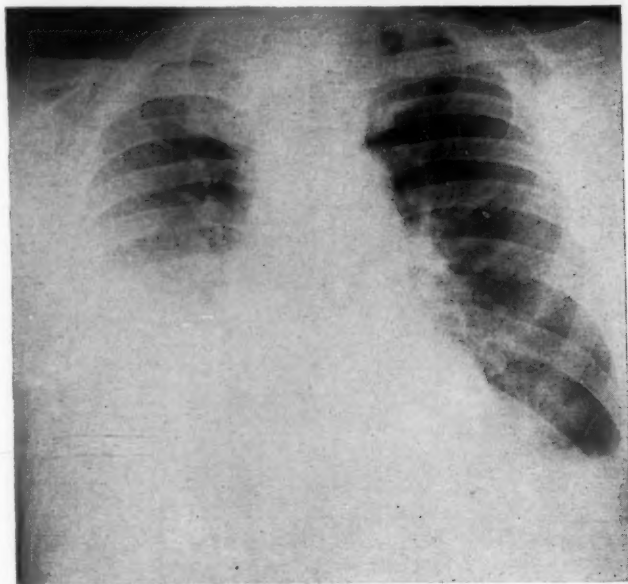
Portable chest X-ray taken May 17, 1946, showing decrease in fluid in left pleural cavity and increase in fluid in right pleural cavity.
